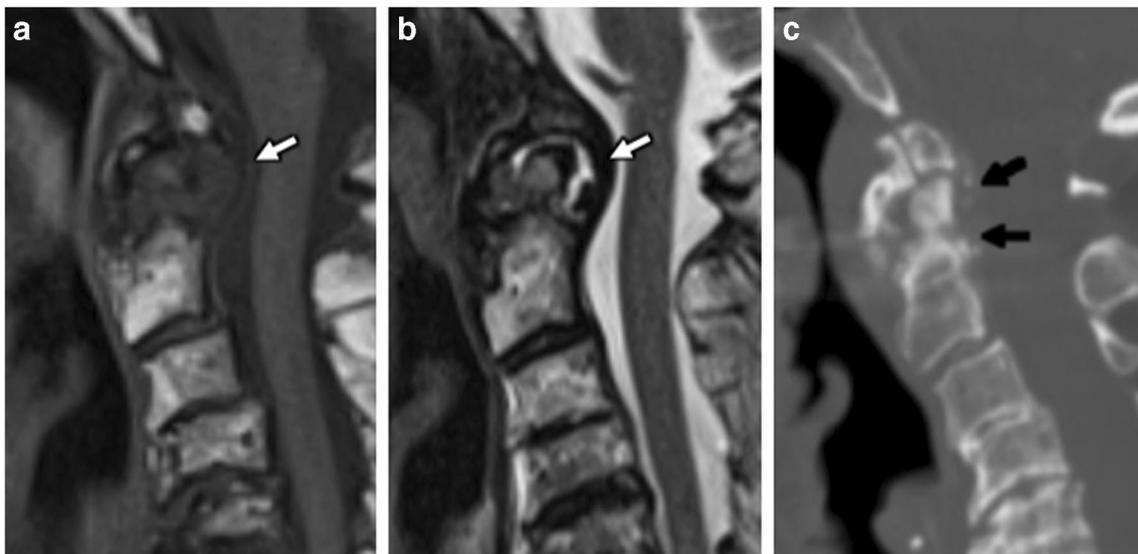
a An 80-year-old woman with no history of RA, with chondrocalcinosis about the dens. Sagittal T1-weighted demonstrates T1 hypointense soft tissue (*arrow*) posterior to the dens. b Sagittal T2-weighted image demonstrates T2 heterogeneously hyperintense soft
